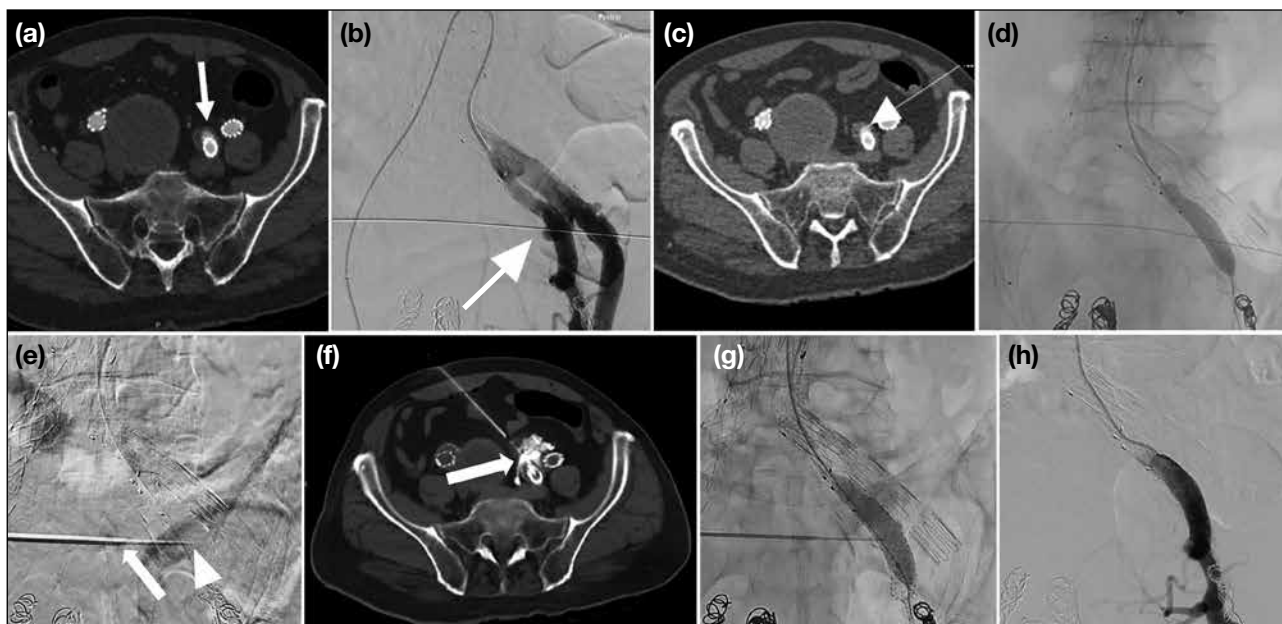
An 86-year-old male patient. (a) Initial computed tomography aortogram showing increase in size of abdominal aortic aneurysm sac and left IIA sac, with only mild endoleak suspected near the left internal iliac limb (arrow). (b, c) Aortogram and angiography-computed tomography (angio-CT) respectively, with intra-arterial injection at common iliac limb at left iliac bifurcation device, confirming left internal iliac limb endoleak (arrows). (d) Successful cannulation of the left internal iliac artery limb and deployment of a 10 mm x 40 mm balloon (Mustang, Boston [MA], US) at the site of the endoleak with position confirmed with angio-CT. (e) Under combined computed tomography (CT) and fluoroscopic guidance, a 17-gauge needle (arrow) [Gangi-SoftGuard; Apriomed, Uppsala, Sweden] was advanced towards the site of the endoleak in the left internal iliac artery (IIA) via the right anterior abdominal wall, through which a 20-gauge Chiba needle (Cook Medical, Bloomington [IN], US) [arrowhead] was introduced to puncture the left IIA endoleak site. (f) The position of the Chiba needle (arrow) was confirmed by CT and fluoroscopy with contrast injection. (g) A 10 mm x 40 mm 135-cm balloon (Mustang; Boston Scientific, Marlborough [MA], US) was inflated to occlude the endoleak site whilst total of 1.5 mL of butyl cyanoacrylate glue (50% dilution with lipiodol) was injected under real time fluoroscopy. The balloon was then withdrawn. (h) Post-embolisation angiogram shows satisfactory obliteration of the left internal iliac limb endoleak.
